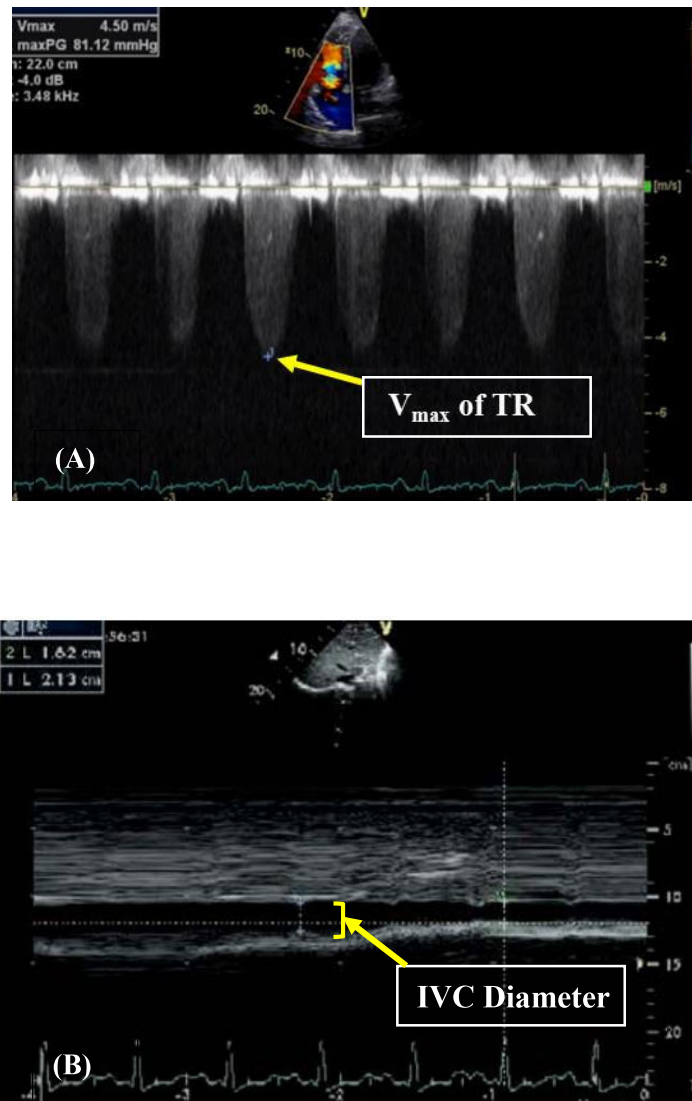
Echocardiographic Parameters. (A) Shows the measurement of maximum velocity (V_{\max}) of TR using continuous-wave tissue Doppler, utilizing the apical 4-chamber view. (B) Shows the estimation of IVC size and collapsibility in the SCIVC (subcostal IVC) view
